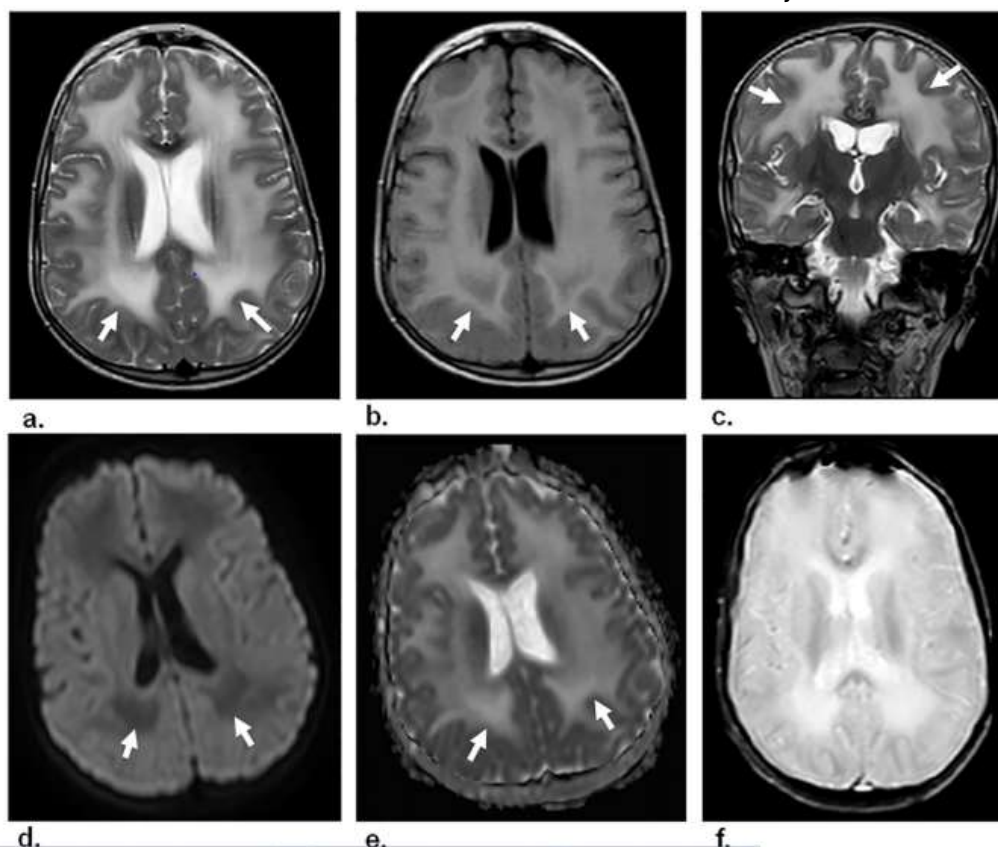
An 11-year-old boy with acute COVID-19 infection presented with fever, cough, and encephalopathy. (a) Axial T2W and (b) Axial FLAIR images demonstrate extensive, confluent white matter hyperintensities (arrows). (c) Coronal T2W imaging confirms these abnormalities (arrows). (d) DWI and (e) ADC map reveal no restricted diffusion (arrows). (f) Axial T2*W image shows no evidence of hemorrhage [67].
